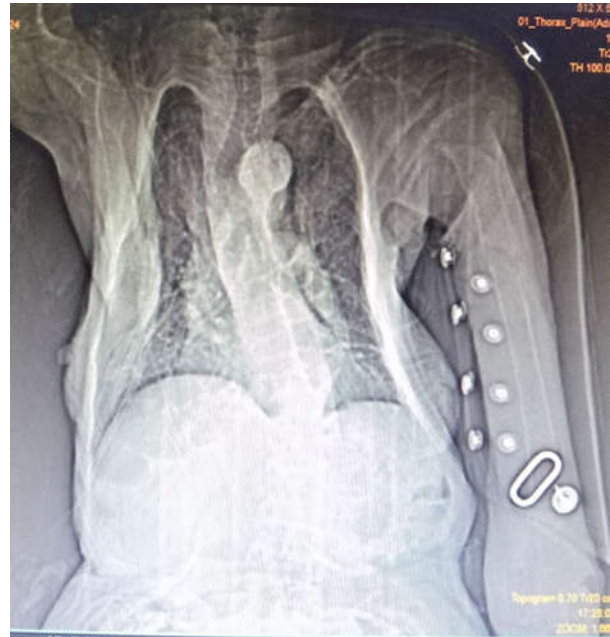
CT Topogram showing cervical and thoracic scoliosis, tracheal deviation and left humerus fracture
